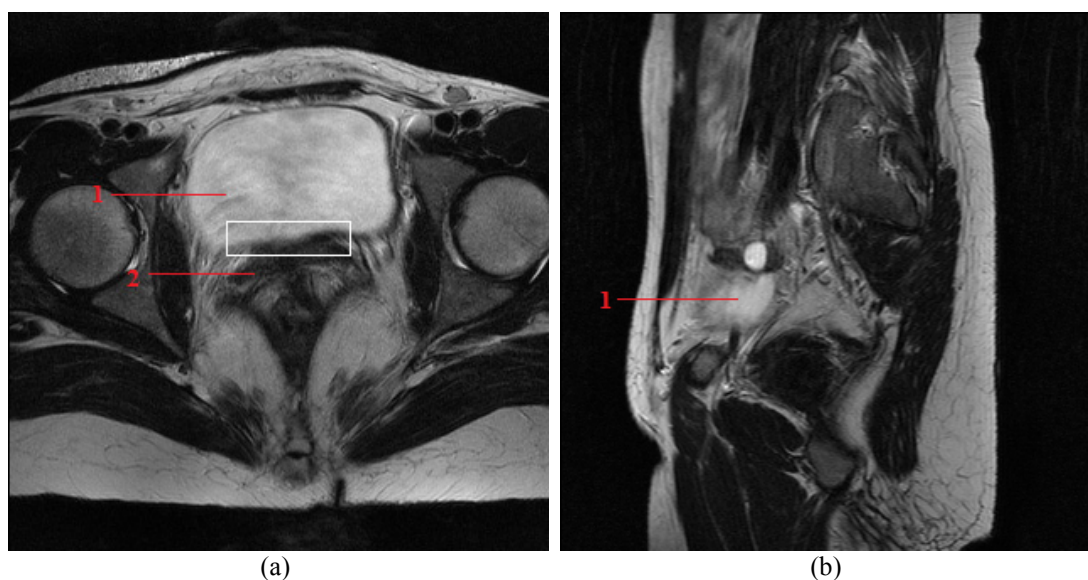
T2-weighted MR images of the female pelvic cavity in which the boundary of the urinary bladder is unclear: (a) axial view, with the blurred posterior bladder region marked by the rectangle; (b) sagittal view (Labels: 1-bladder; 2-vagina).
